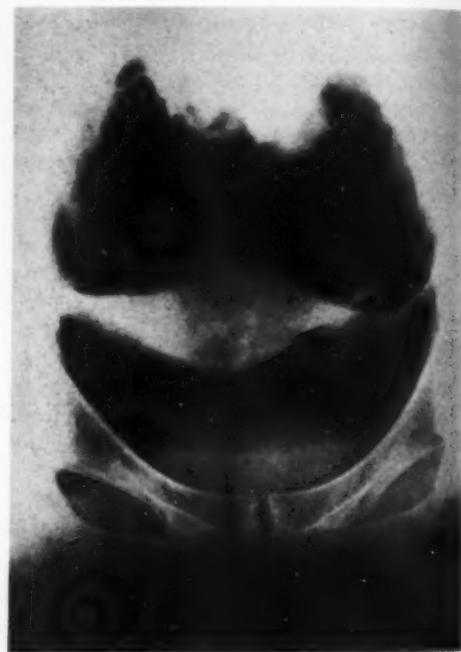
Roentgenographic examination of the pelvis along the pelvic axis discloses the pelvic organs and often gives information as to the degree of involvement, which is of value in treatment. The uterus is seen "on end" with tubes and ovaries on either side; the rectum posteriorly was left partially filled to indicate its position.
